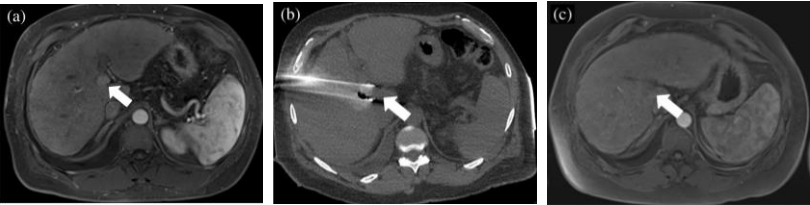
(Yun et al.): The patient underwent liver-directed IRE after a multidisciplinary tumor board discussion (a) pre-procedural MRI imaging demonstrates an enhancing mass (arrow) near the hepatic hilum. (b) intraprocedural CT imaging demonstrates two parallel probes with an enhancing zone of ablation in between the probes. Gas within the lesion (arrow) is an expected finding due to the dissociation of gases from the blood. (c) post-ablation 3-month follow-up MRI reveals hypoaattenuation and lack of enhancement of the ablation target (arrow).
